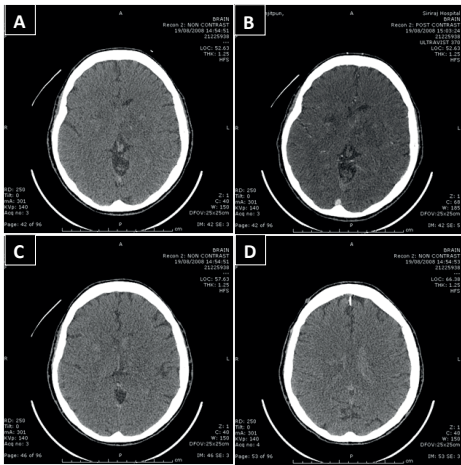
A 48 year-old woman with known diagnosis of NF1, presented with a recent onset of global aphasia, GCS 11/15. CT brain non-contrast study revealed clot in bilateral internal cerebral veins, intracerebral hemorrhage at bilateral thalamus with edema (A,C) and intraventricular hemorrhage in frontal horn of both lateral ventricles, no brain herniation (D). CT brain with contrast study showed filling defect in bilateral internal cerebral veins that confirmed deep cerebral venous sinus thrombosis (DCVST). Pretreatment mRS score = 5, then after anticoagulant therapy with no surgical intervention and she died ten days later with no autopsy, posttreatment mRS score = 6 poor outcome.
